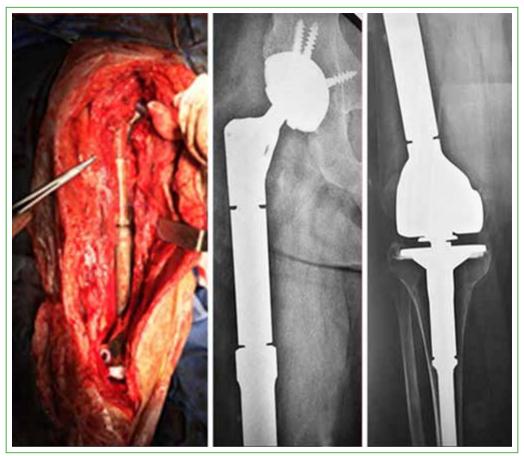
Extended posterolateral approach and postoperative radiographic control.
